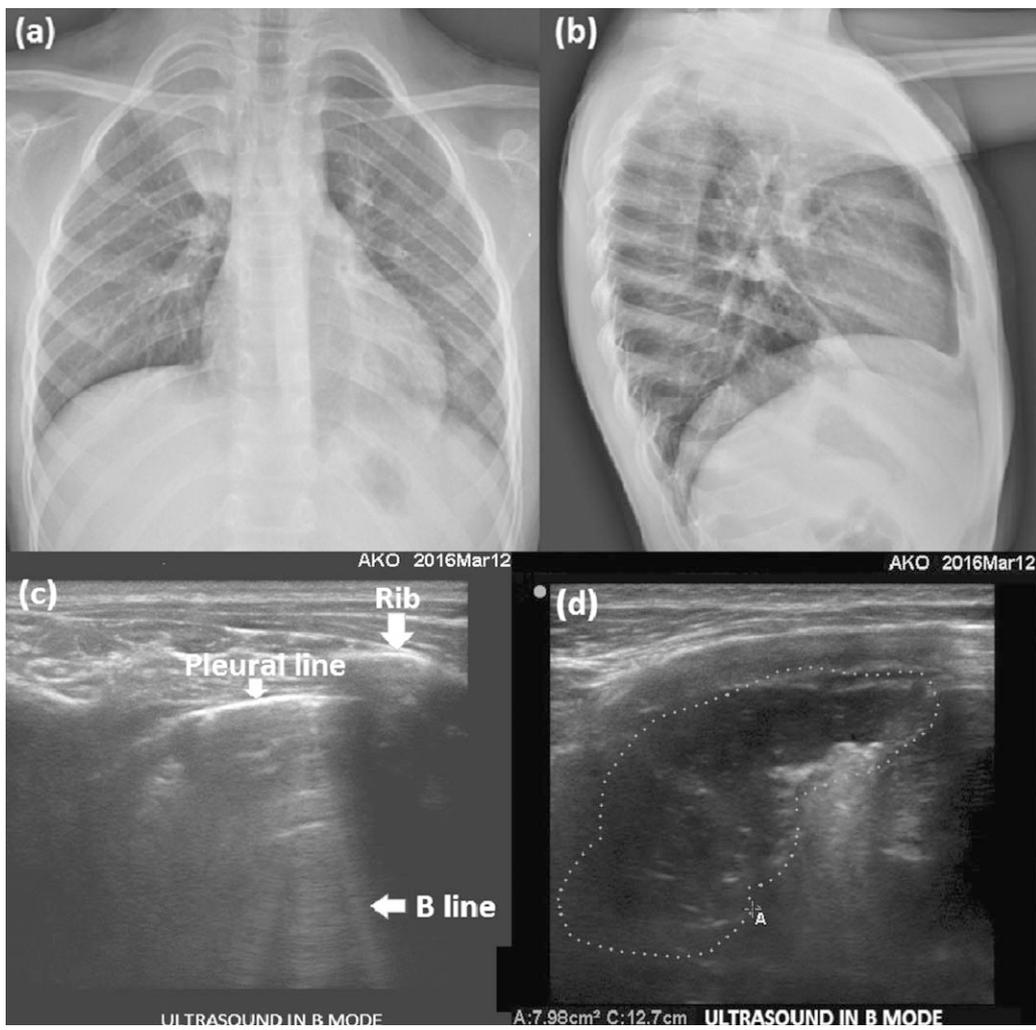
(a) Radio-opacity extending to the apex in the right upper zone at posterior-anterior chest X-ray, (b) radio-opaque appearance originating from the hilar region and extending to the apex. (c) B-lines tending to coalescence and (d) a 7.98-cm² area compatible with atelectasis at lung ultrasonography evaluation.
